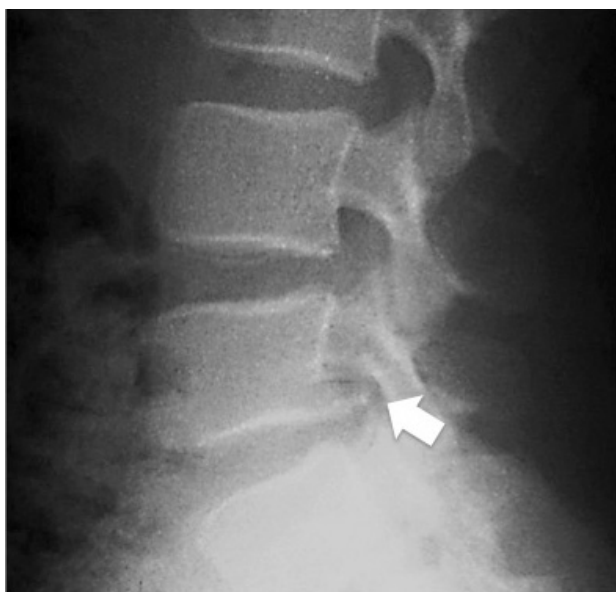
Lateral plain radiograph showing a bony fragment (arrowed) posterior to the upper L4 endplate
